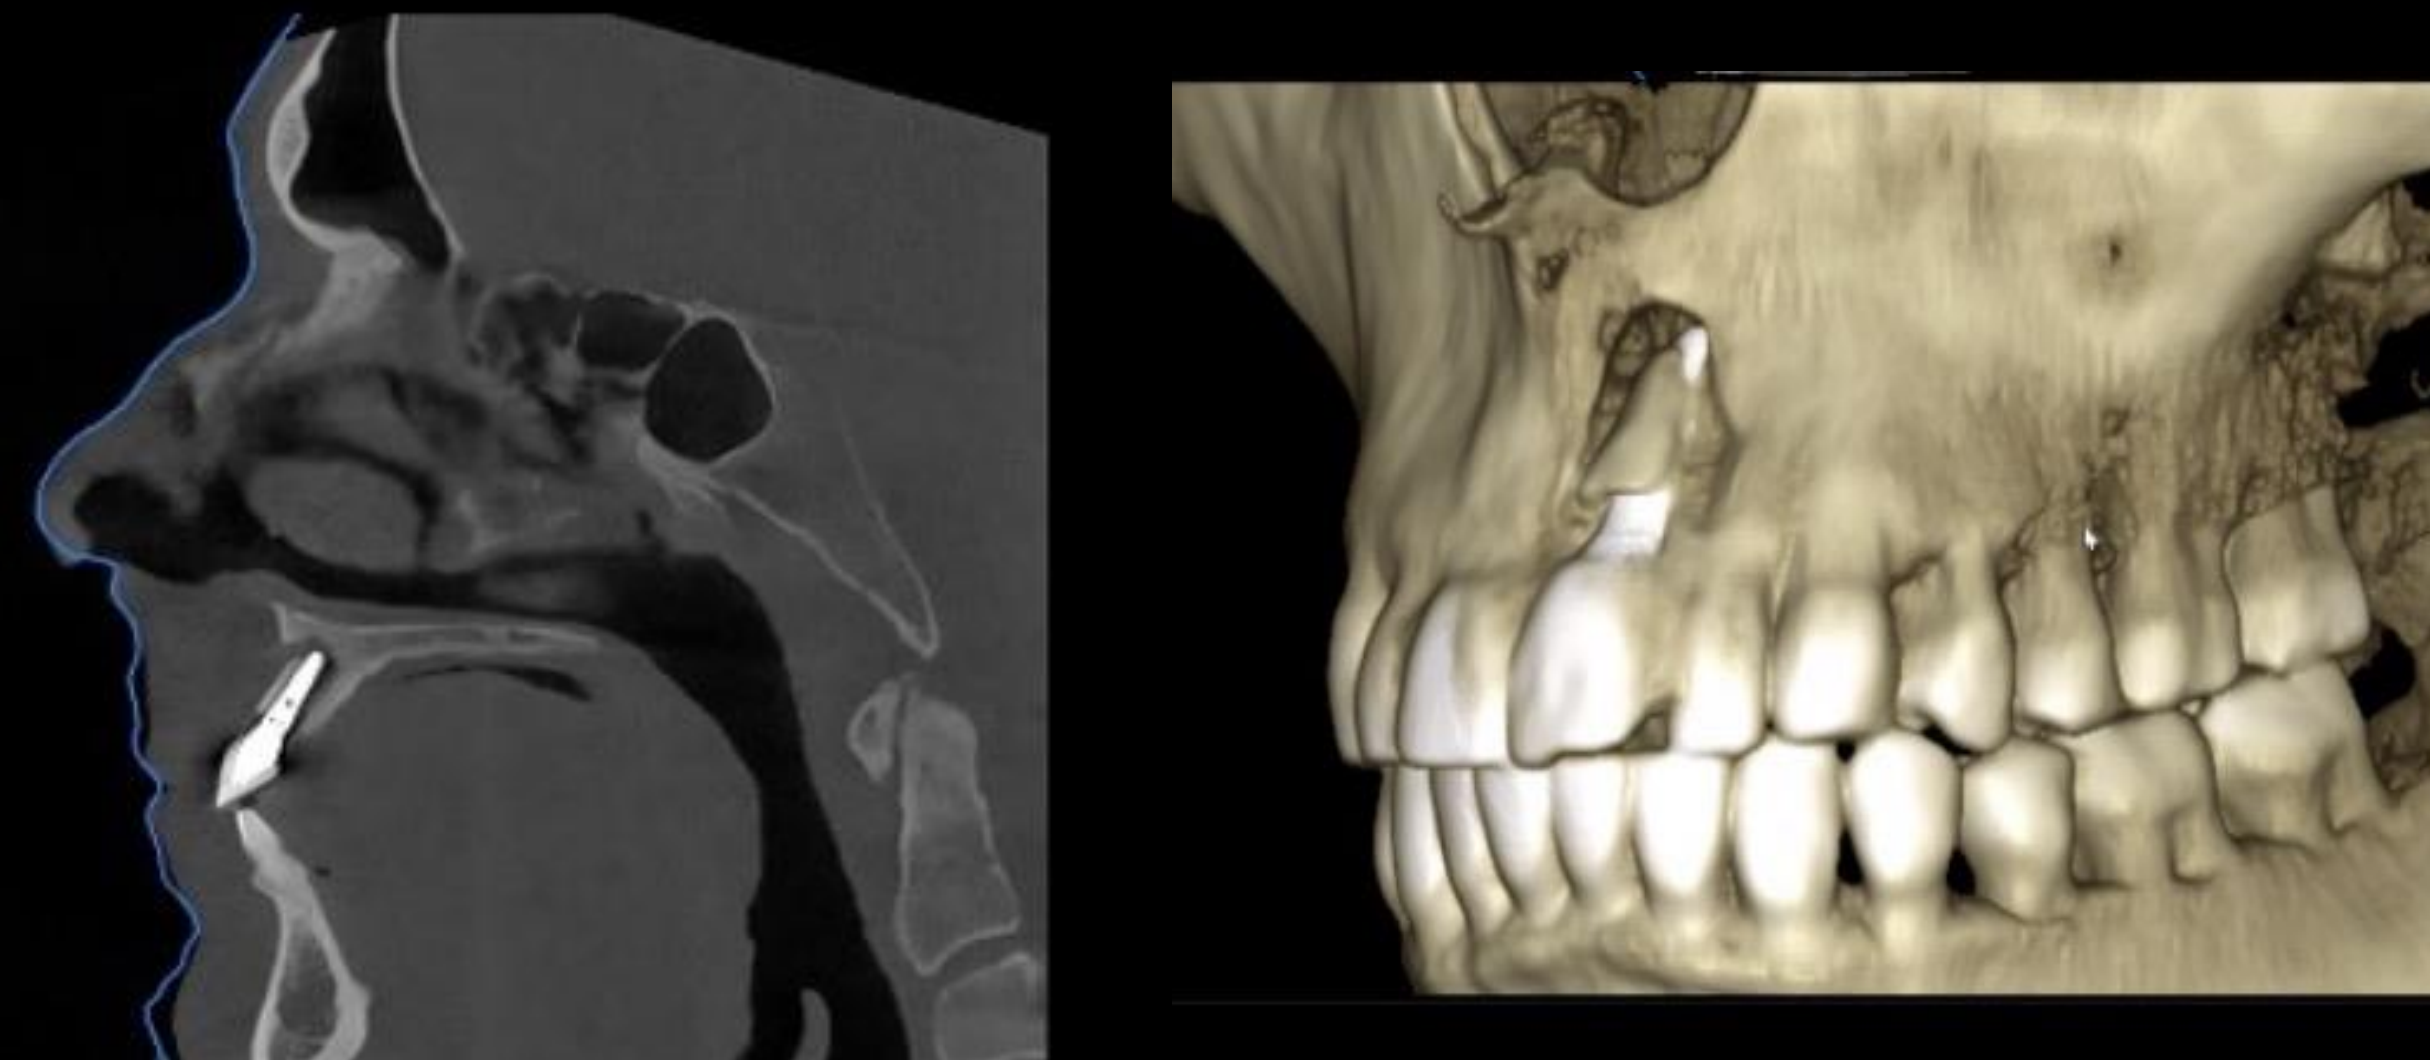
CBCT volumetric reconstruction revealing extensive circumferential peri-implant bone destruction around implant site #9.
